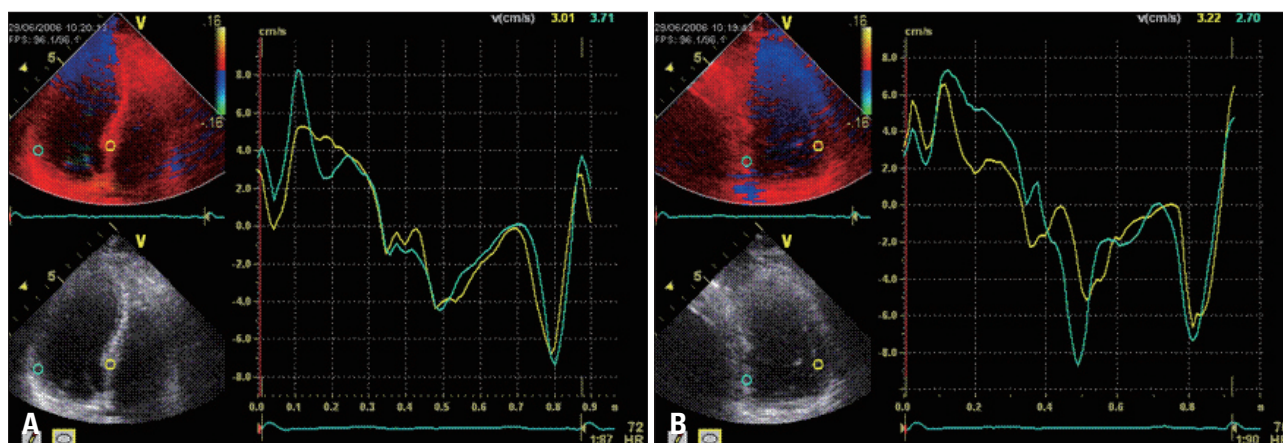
Doppler tissue imaging for offline color tissue velocity imaging in the apical 4 chamber (A), and 2 chamber (B) image.
